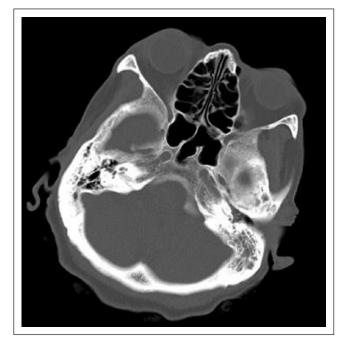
CT head showing left and right mastoid air cell effusion.
